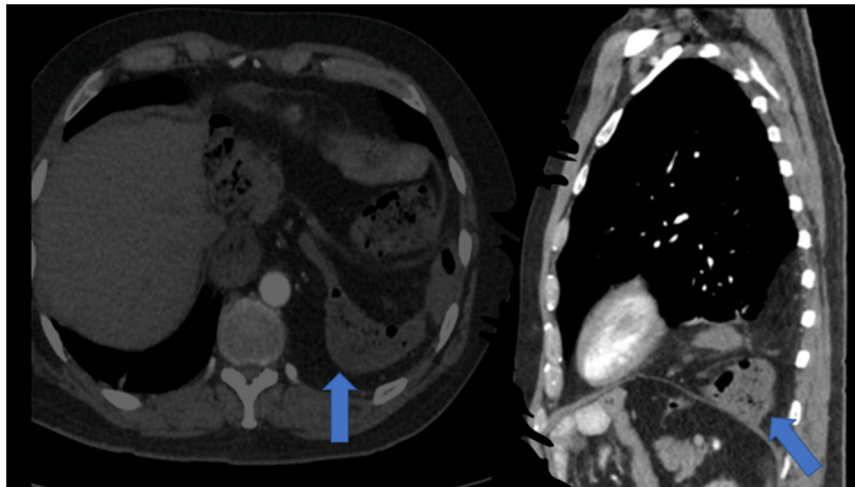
Sagittal (A) and axial (B) images from the patient’s computed tomography scan demonstrating paraconduit herniation of the splenic flexure of the colon through the esophageal hiatus (*blue arrows*).
